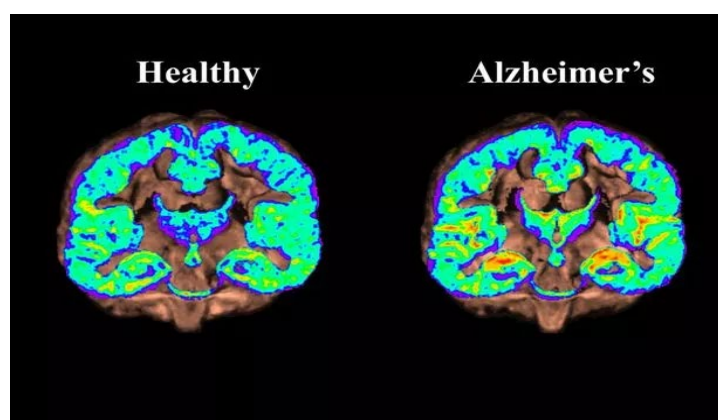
Image of brain mapped using MRI. Left (Healthy)
